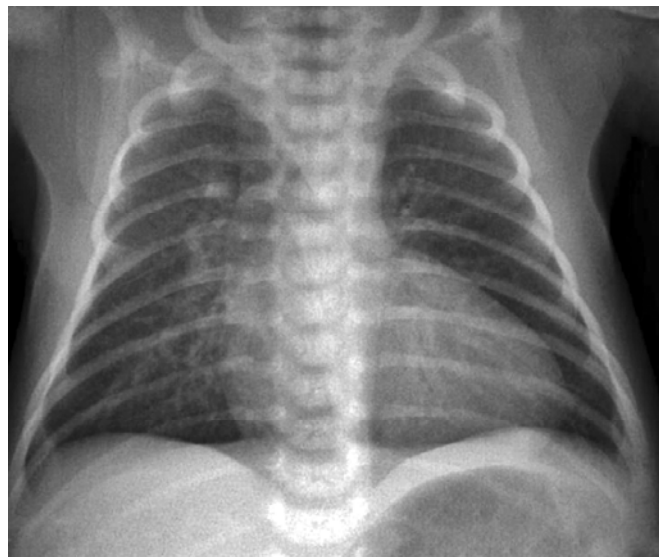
Chest X-ray—transposition of the great arteries
